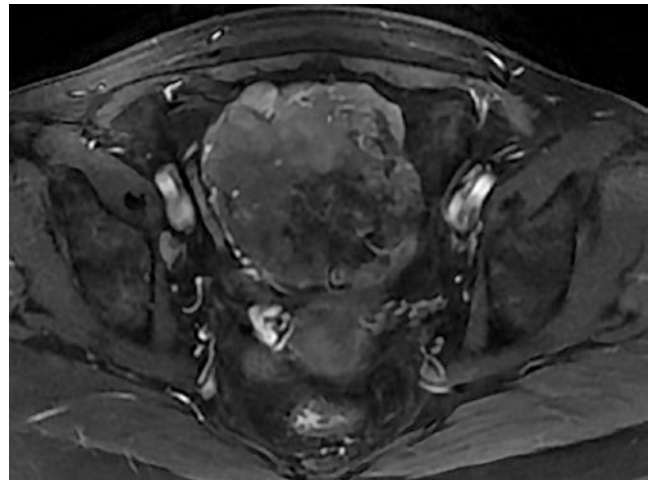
T1-weighted contrast-enhanced image showed the mass had heterogeneous enhancement
